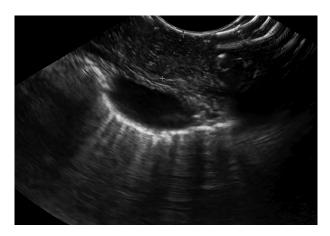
Endosonography evaluation of the esophageal neoplastic lesion
